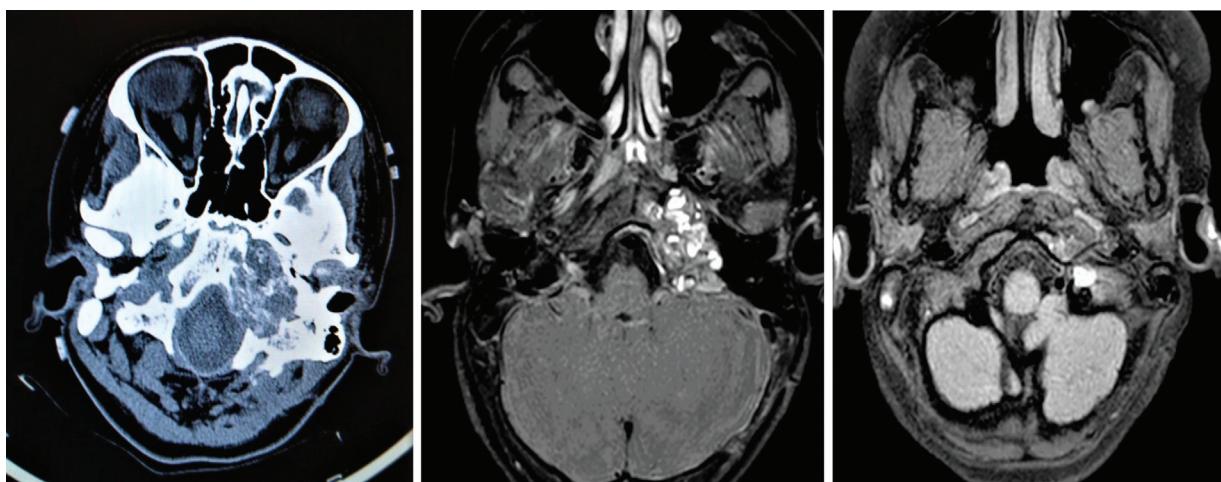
Aggressive osteoblastoma: Computed tomography of the skull revealing an osteoblastic lesion (5.2 cm in the largest dimension) arising in the petrous portion of the left temporal bone.
